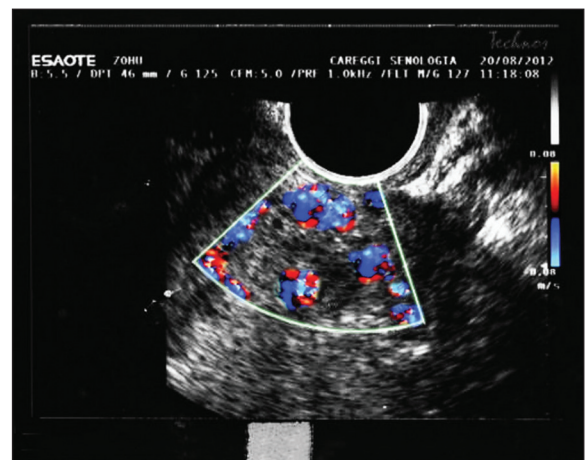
Ultrasound color Doppler applied to the cervix, showing a highly vascularized zone
